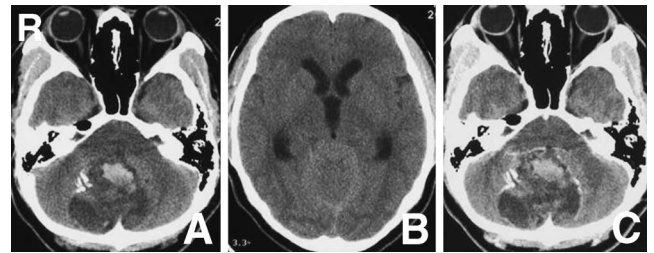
Neuroimaging findings at age 21 years. A, B: Axial computed tomography scans on admission showing a tumor at the posterior fossa with a maximum diameter of 55 mm with intratumoral hemorrhage, calcification, and cystic components (A), acute obstructive hydrocephalus, and upward herniation (B). C: Axial computed tomography scan with contrast medium showing slight enhancement of the tumor capsule.
